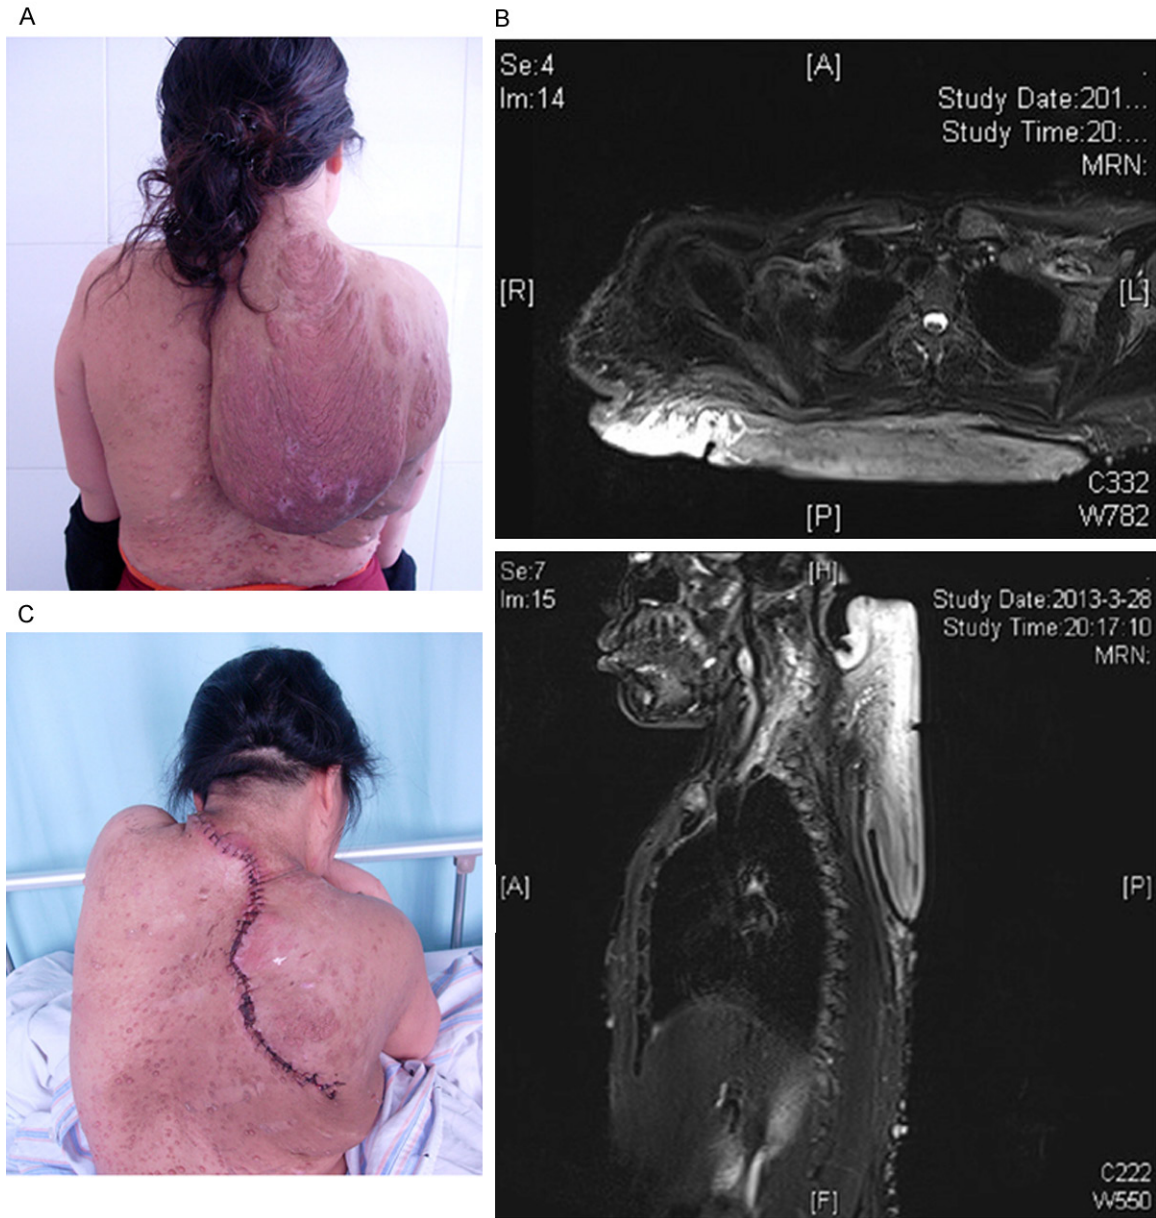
Case 3. A 40-year-old woman had a giant neurofibroma in the neck and back (A). MRI showed that the tumor invaded into the deep fascia and muscles with ill-defined boundary (B). The tumor was partially resected and the wound was repaired by skin flap (C).
